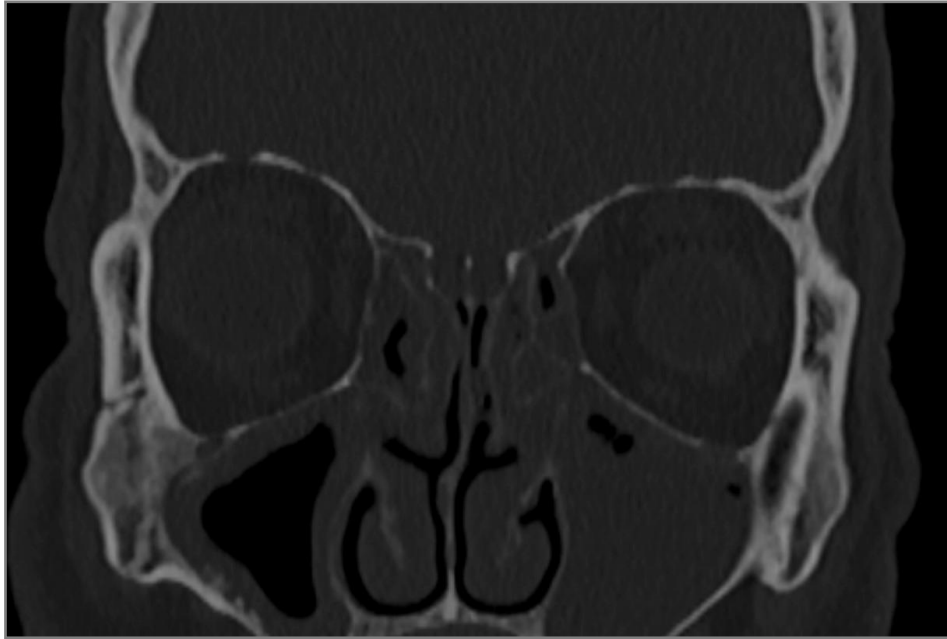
CT (coronal section) of a patient with pansinusitis and Keros 2 olfactory fossa.
